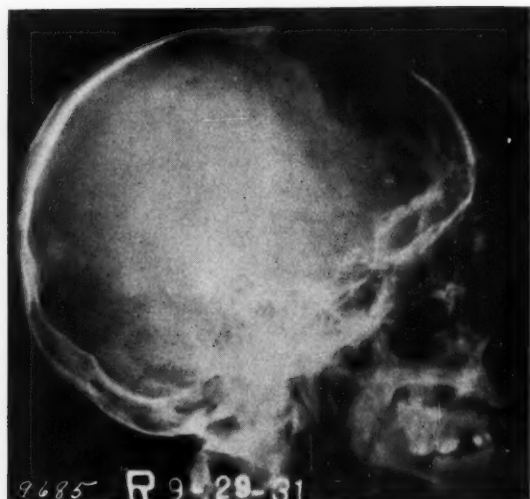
X-ray taken 102 days from onset of osteomyelitis, showing destruction of outer and inner table of the skull.
